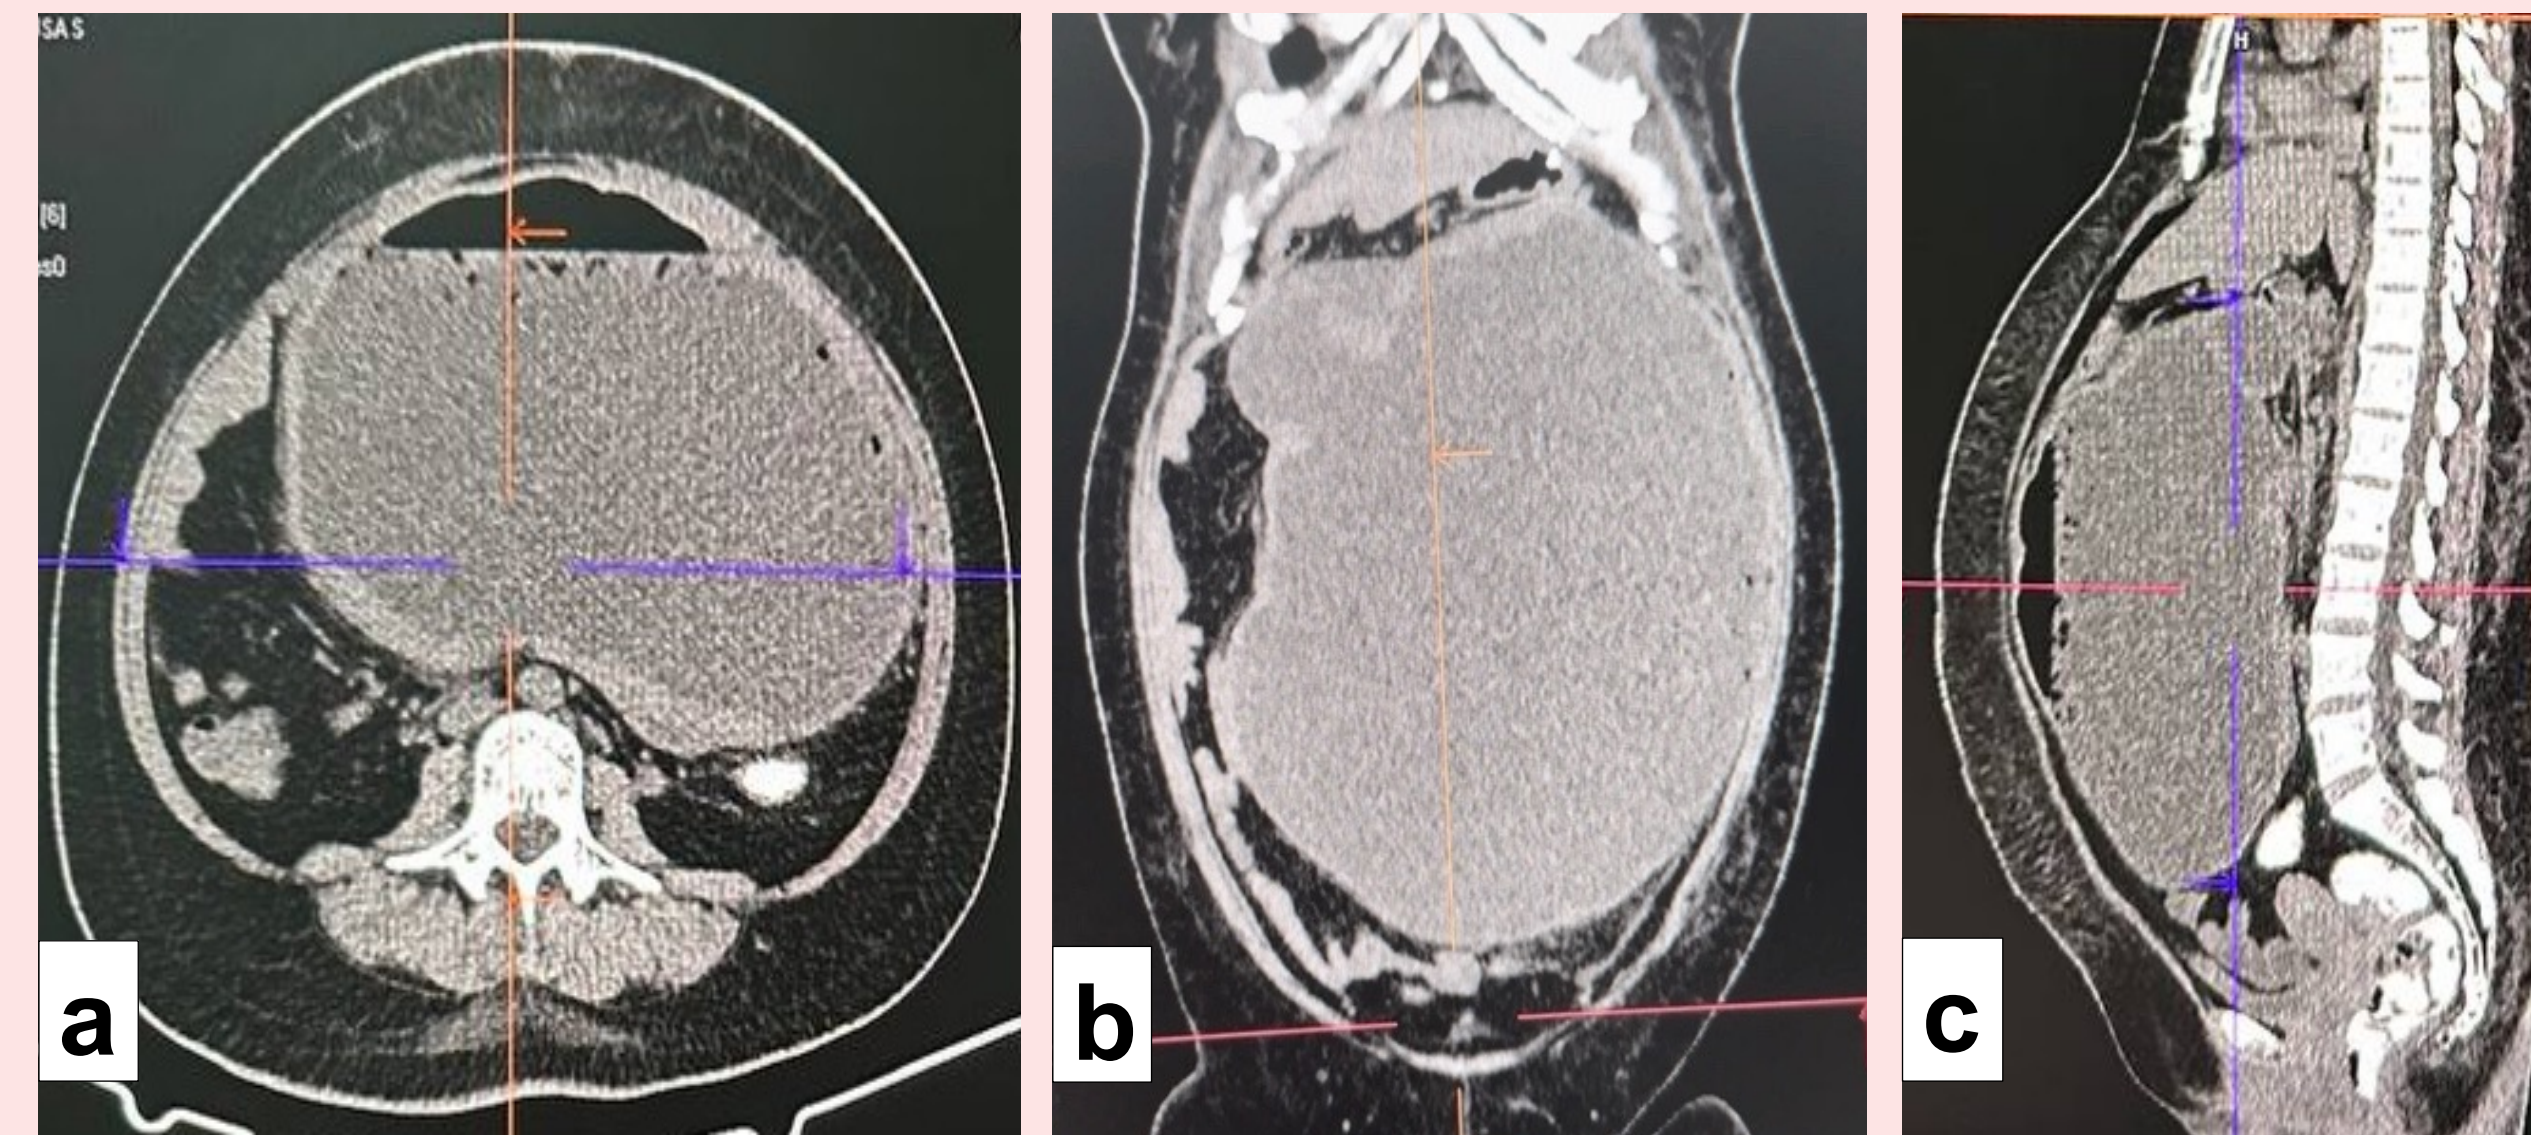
CT Scan of the Whole abdomen with IV contrast revealing a proximal jejunal dilatation which is homogenous with peripheral rim enhancement suggestive of a pseudocapsule. There was minimal ascites but no pneumoperitoneum. (a) Axial view (b) Coronal view: the red arrow indicates a connection between the proximal jejunum and the pseudocapsule. Other abdominal structures were also seen being pushed towards the periphery by the very large pseudocapsule (c) sagittal view
